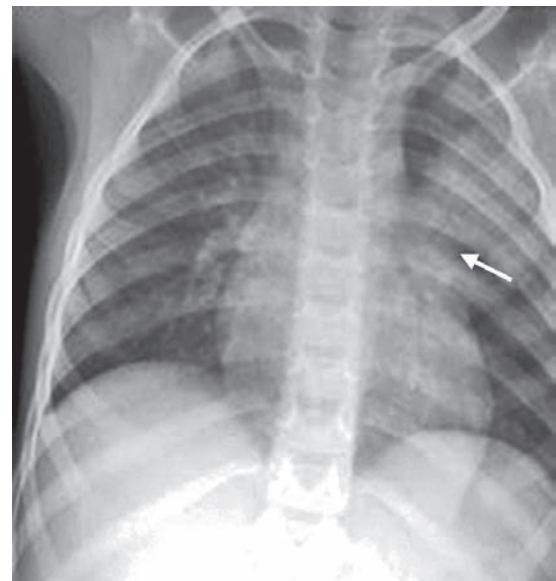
Bacterial infections present as lobar or segmental consolidations or fluffy infiltrates. Even though consolidation may be extensive, volume loss may be minimal. The organisms are commonly *Haemophilus influenzae* in infants less than 2 years and *Streptococcus pneumoniae* in older children. Chest X-ray (CXR) showing segmental consolidation in the left upper lobe with air bronchograms (white arrow)
